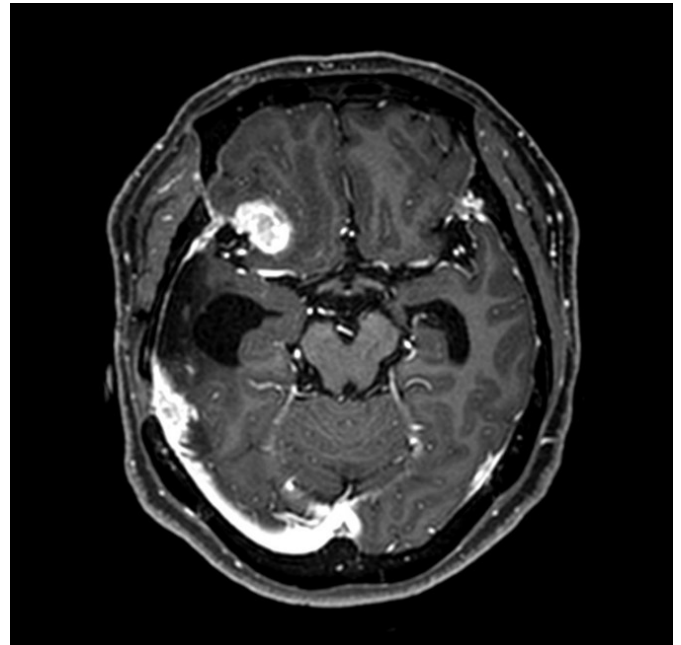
Eight years after the initial surgery, brain magnetic resonance images revealed an increase in the size of the remnant tumor in frontal lobe.
